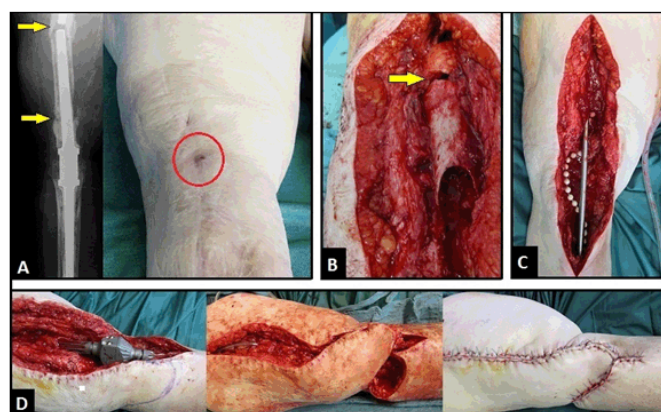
(A) Posteroanterior (PA) radiograph and clinical photograph showing the failed arthrodesis nail and chronic fistula of the knee joint (circle), note the fractures of nail and femoral bone proximally and non-union distally (arrows), (B) Clinical photograph showing large bony defect after removal of nail and the fracture of femoral bone (arrow), (C) Clinical photograph showing temporary intramedullary stabilization and incorporation of PMMA beads, (D) Clinical photographs demonstrating wound closure with the medial random skin transposition flap.
